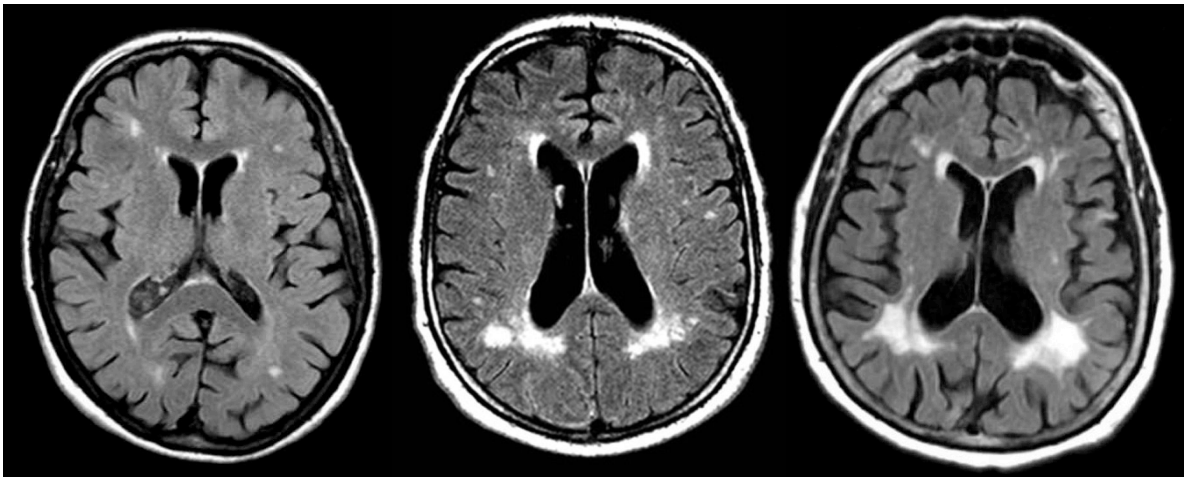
Different burden of white matter hyperintensities showed on FLAIR images.
